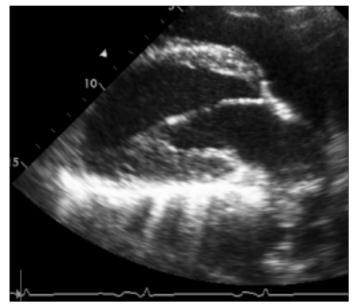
Parasternal long axis view showing apical bulging of the left ventricle through the defect
